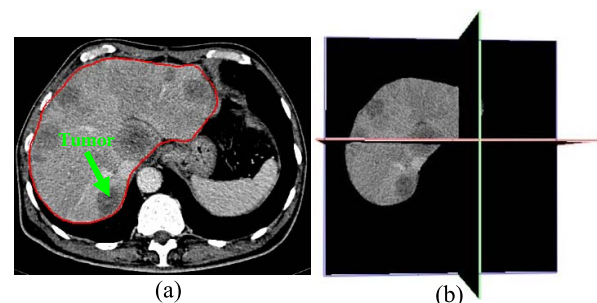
The original CT slice and the segmented orthogonal liver slice from an abdominal CT volume.
